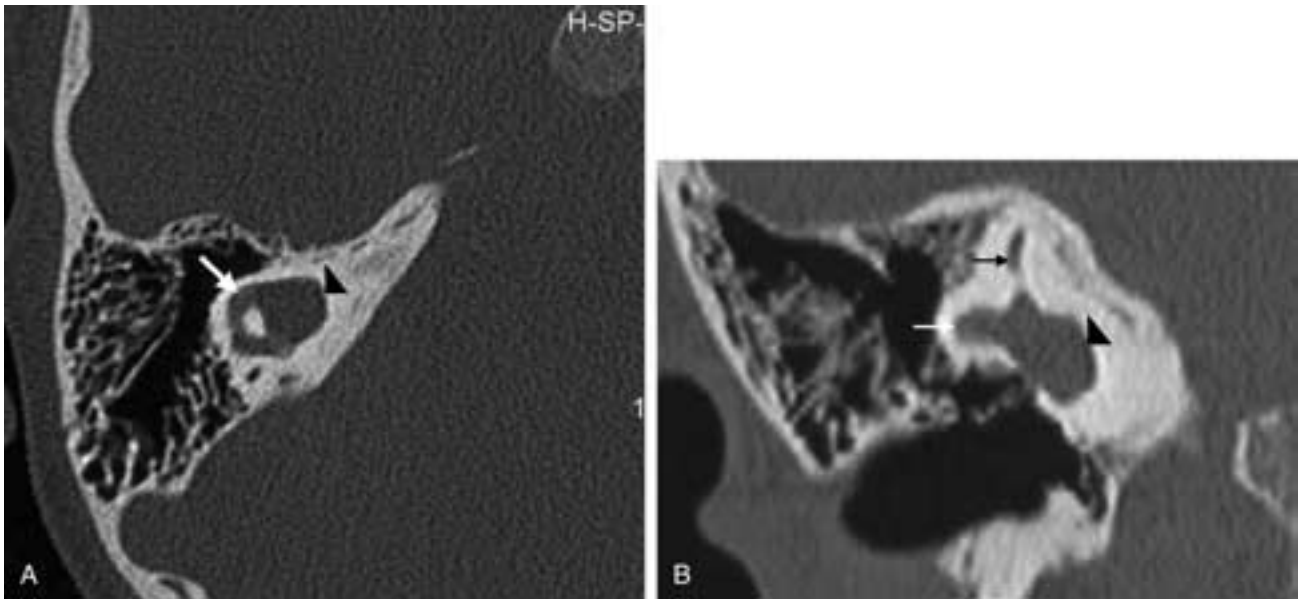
Enlarged vestibule. A, Axial CT image showing enlarged vestibule (*black arrowhead*) and partial incorporation of a widened lateral semicircular canal (*white arrow*). B, Coronal CT image of the same patient showing the same condition as in A (*black arrow* = normal superior semicircular canal, *white arrow* = widened lateral semicircular canal, *black arrowhead* = enlarged vestibule).
